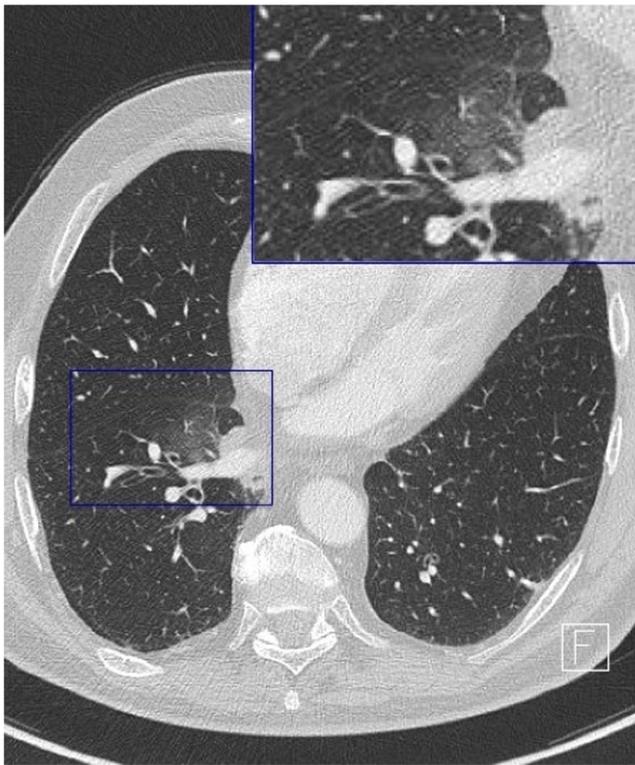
Computed tomography depicting opacification due to perivenous hemorrhage around the right inferior pulmonary vein in a 77-year-old male patient
